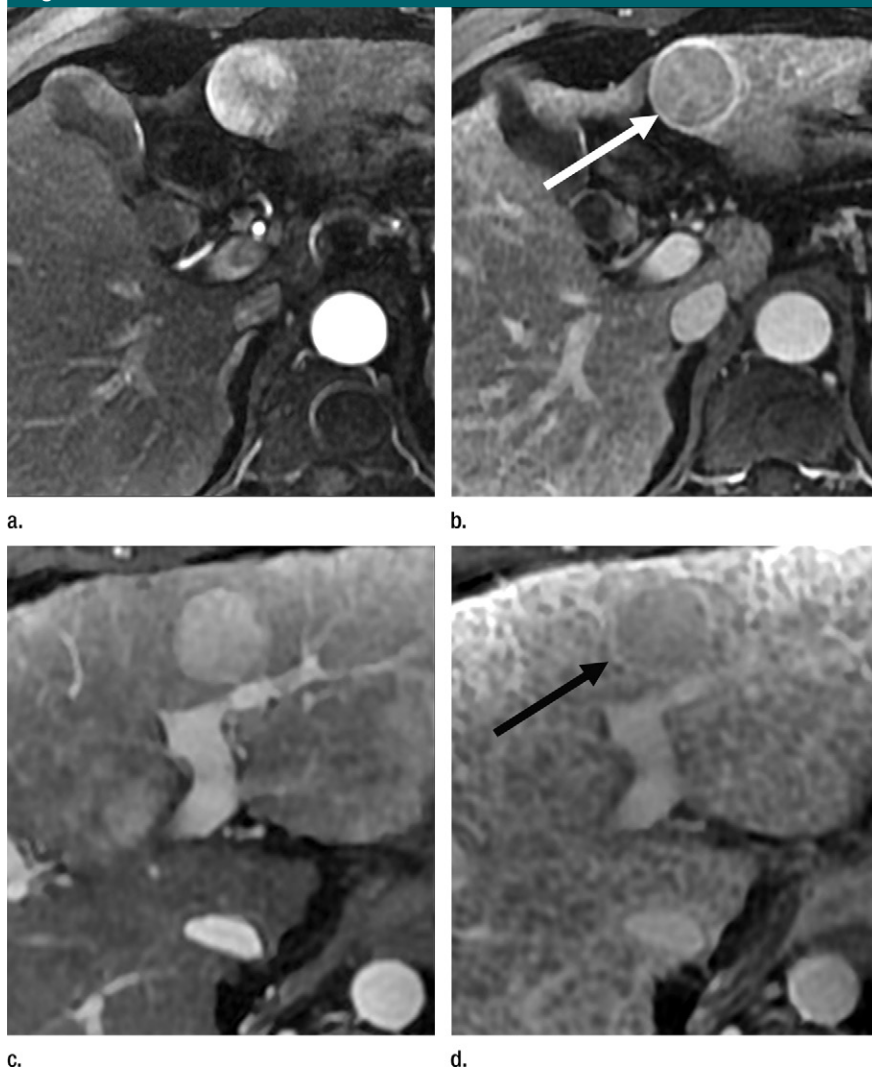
HCCs with and without definite capsule appearance. (a, b) HCC with definite capsule appearance in a 54-year-old man with hepatitis C-related cirrhosis. T1-weighted 3D GRE MR images with fat suppression (3.0/1.4; 15° flip angle) obtained in (a) late hepatic arterial phase and (b) 3-minute delayed phase after administration of gadolinium-based contrast agent show 3.2-cm HCC in left lobe. Peripheral enhancing rim (arrow) in delayed phase is unequivocally thicker and more conspicuous than enhancing fibrosis surrounding background nodules, consistent with capsule appearance. (c, d) HCC without definite capsule appearance in 35-year-old man with hepatitis C-related cirrhosis. T1-weighted 3D GRE MR images with fat suppression (3.0/1.4; 15° flip angle) obtained in (c) late hepatic arterial phase and (d) 3-minute delayed phase after administration of gadolinium-based contrast agent show 2.5-cm HCC in left lobe. Peripheral enhancing rim (arrow) in delayed phase is of similar thickness and conspicuity as enhancing fibrosis surrounding background nodules.
